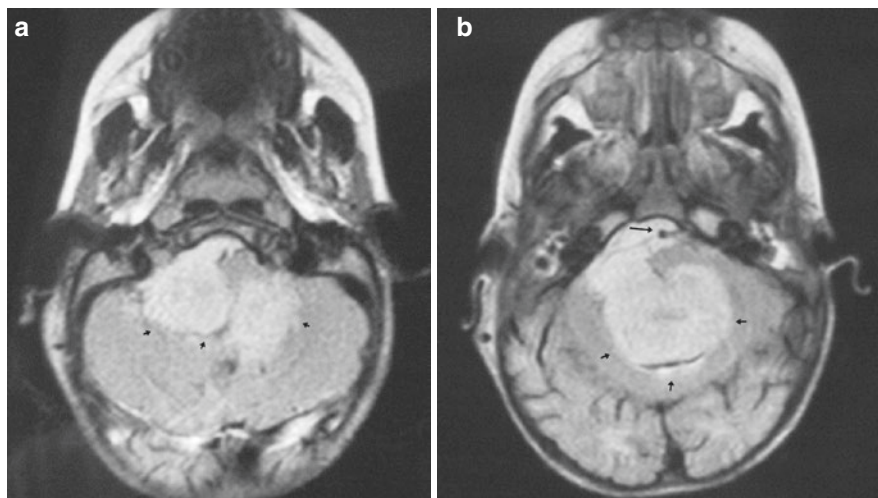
Fluid attenuated inversion recovery MRI (a, b) of an ependymoma (arrowheads) displacing the brainstem and extending into cerebellopontine angle. Encasement of the basilar artery is seen (arrow). The lesion was totally excised via a transvermian approach
